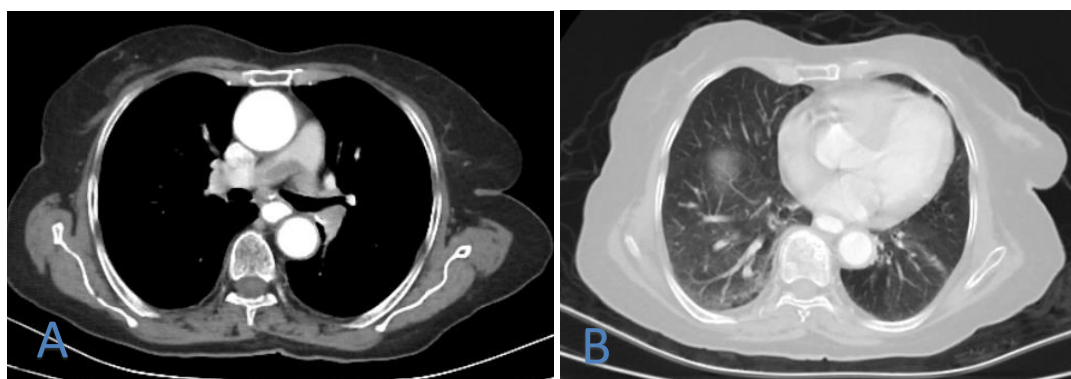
(A) CTPA axial image showing saddle shaped pulmonary embolism. (B) axial lung window HRCT image showing bilateral basal few atelectatic bands.
